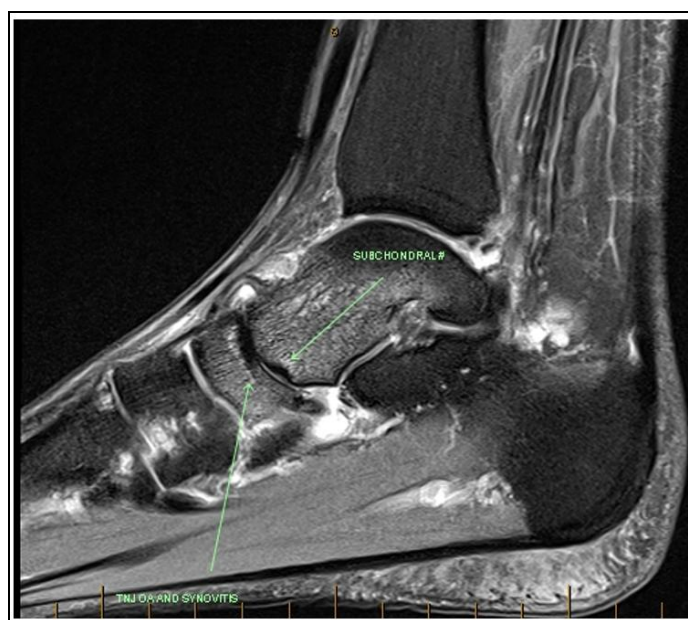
Sagittal FS T2 MRI demonstrating subchondral fracture at the talonavicular joint (TNJ).
